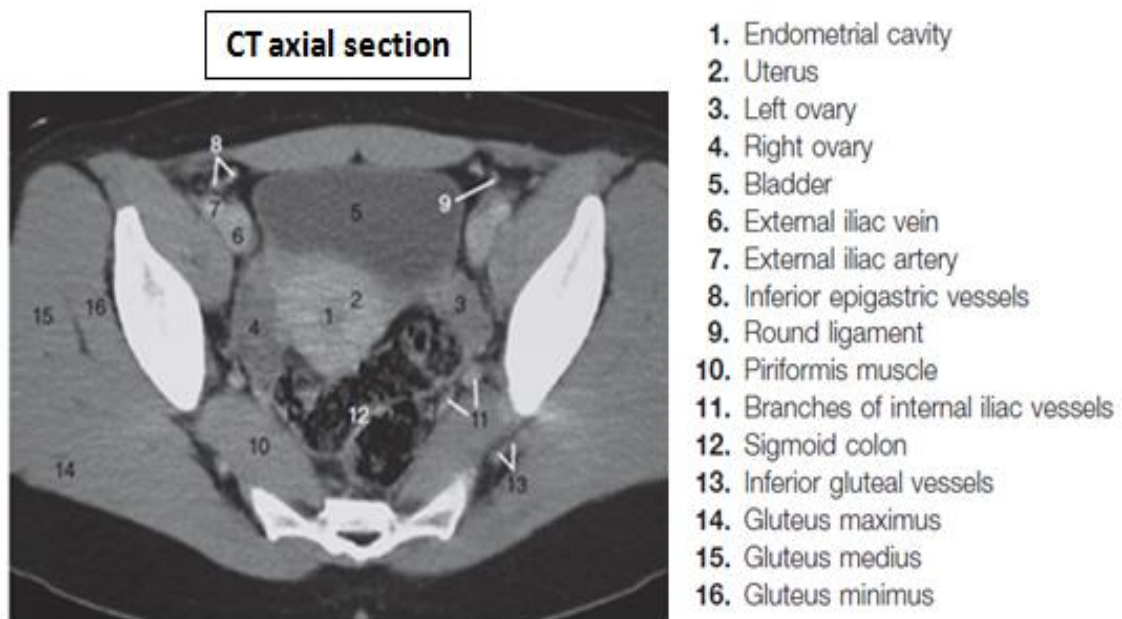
CT axial section of normal female pelvis
